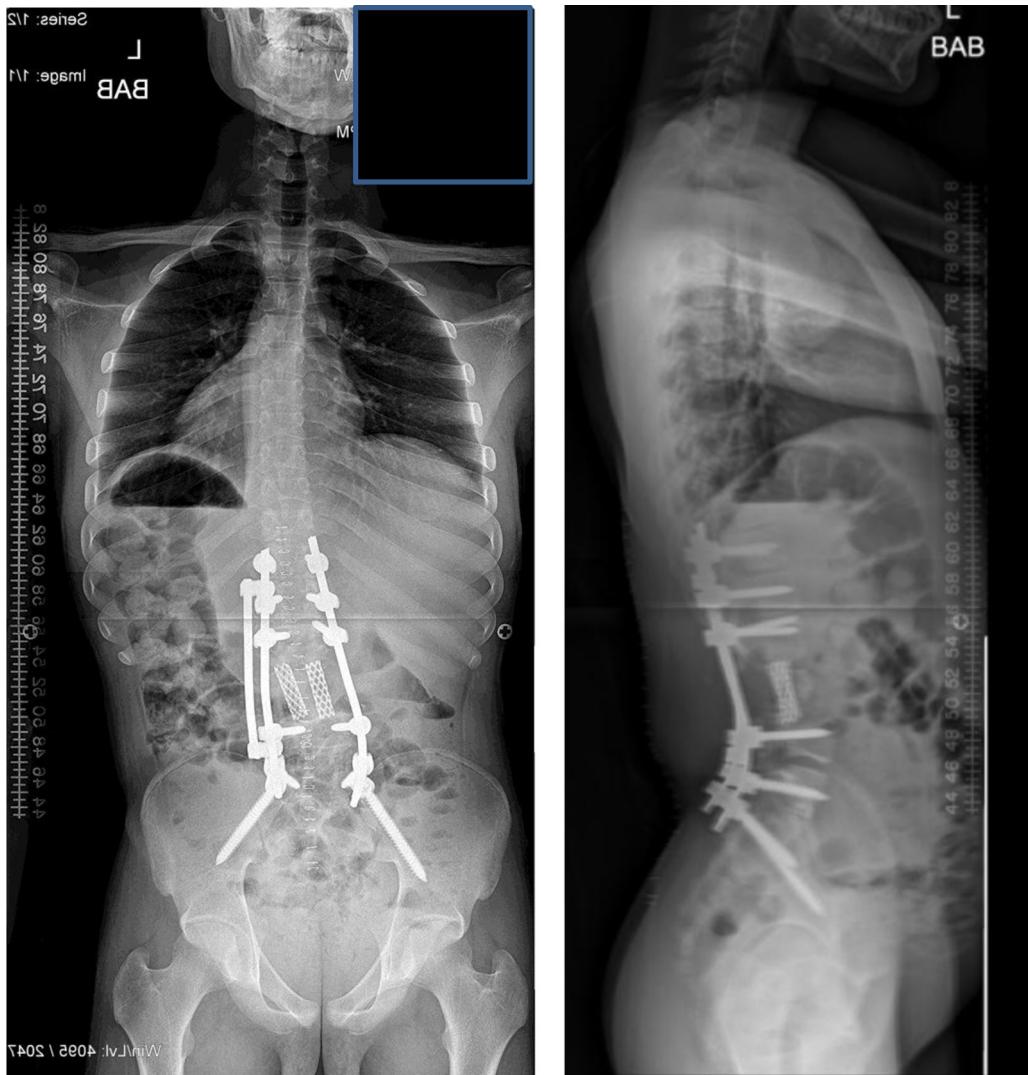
Postoperative standing posteroanterior and lateral scoliosis radiographs.
